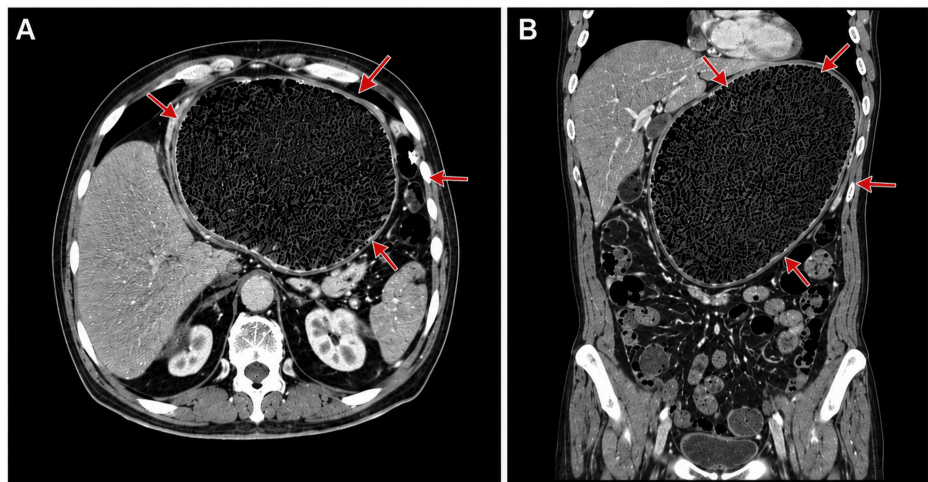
Abdominal CT showing gastric distension.
